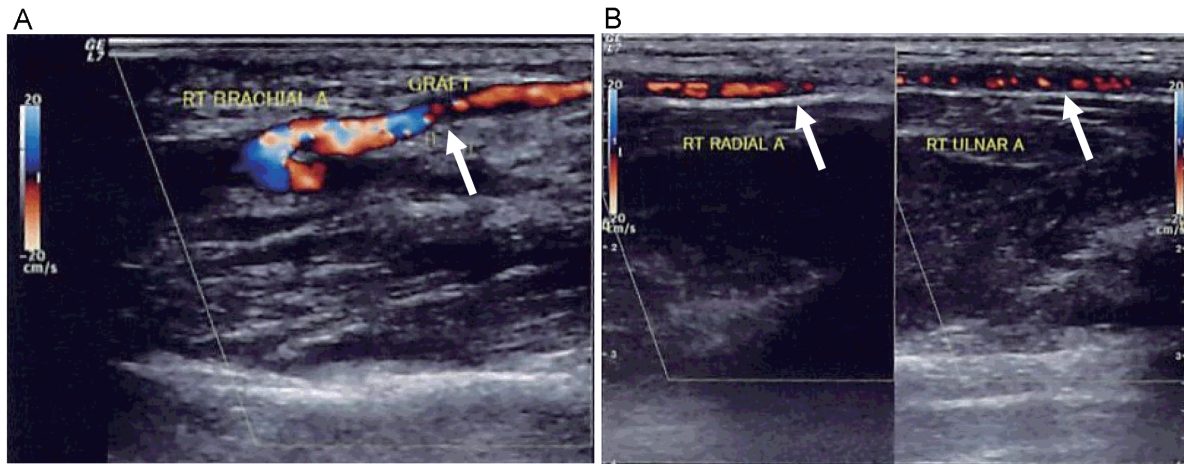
Duplex-sonography 6 weeks after the revascularisation surgery. Duplex-sonography showing favourable blood flow inside: (A) the graft (arrow) and (B) the radial and ulnar arteries (arrow).
